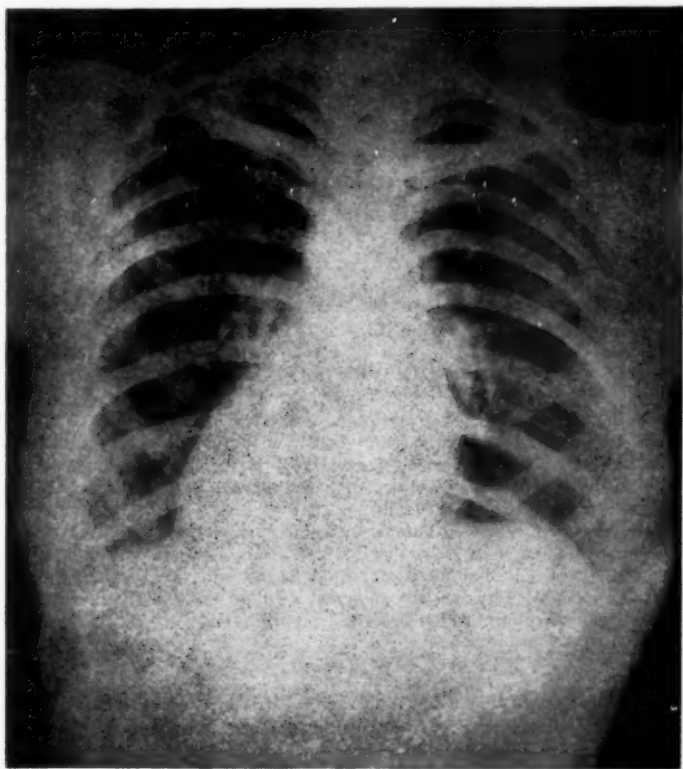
Roentgenogram of the chest, Oct. 17, 1945. "The lungs show good illumination. There are relatively heavy root shadows on both sides. The diaphragms are clear. The heart shadow is moderately large. The cardiothoracic ratio is 13.5/26.5. The aortic shadow is not enlarged. Conclusions: There is slight enlargement of the heart, with fairly heavy hilar markings. When compared with a chest film of August 13, 1945, the earlier roentgenogram disclosed normal root shadows and a normal cardiothoracic ratio of 12/26."
